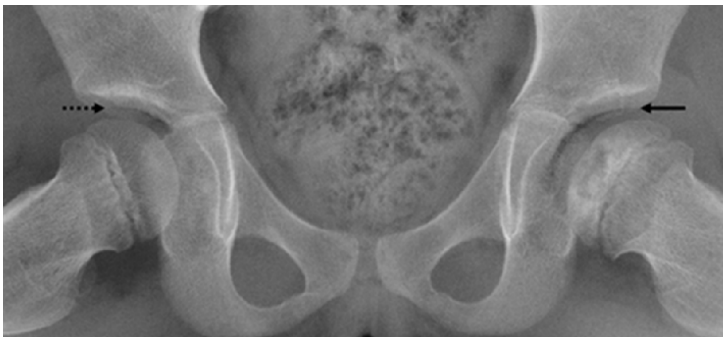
Radiographic appearance of the vacuum phenomenon in the right and left hips of a 6-year-old girl with Legg-Calvé-Perthes disease in the left femoral head. Note the crescent lucency in the left hip, which is a complete type (solid arrow). The linear lucency in the right hip is a partial type (dotted arrow).
